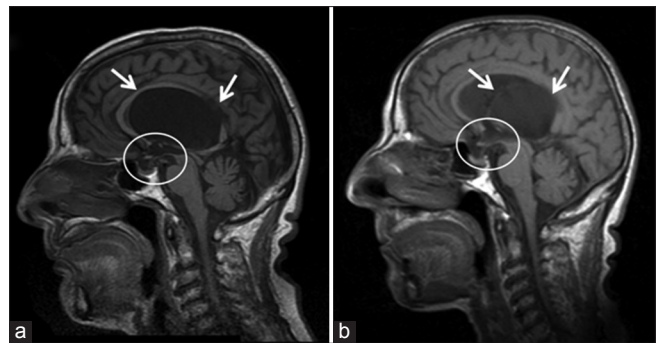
Case 1. (a) Preoperative T1-weighted, sagittal plane image: The cyst (arrows) determines biventricular hydrocephalus developing over the third ventricle that is downward displaced (circle); note also the compression of both pituitary gland and its stalk (circle). (b) The postoperative corresponding magnetic resonance image shows the shrinkage of the cyst (arrows), re-expansion of the third ventricle, patency of the foramen of Monro as well as the decompression of pituitary complex (circle)
